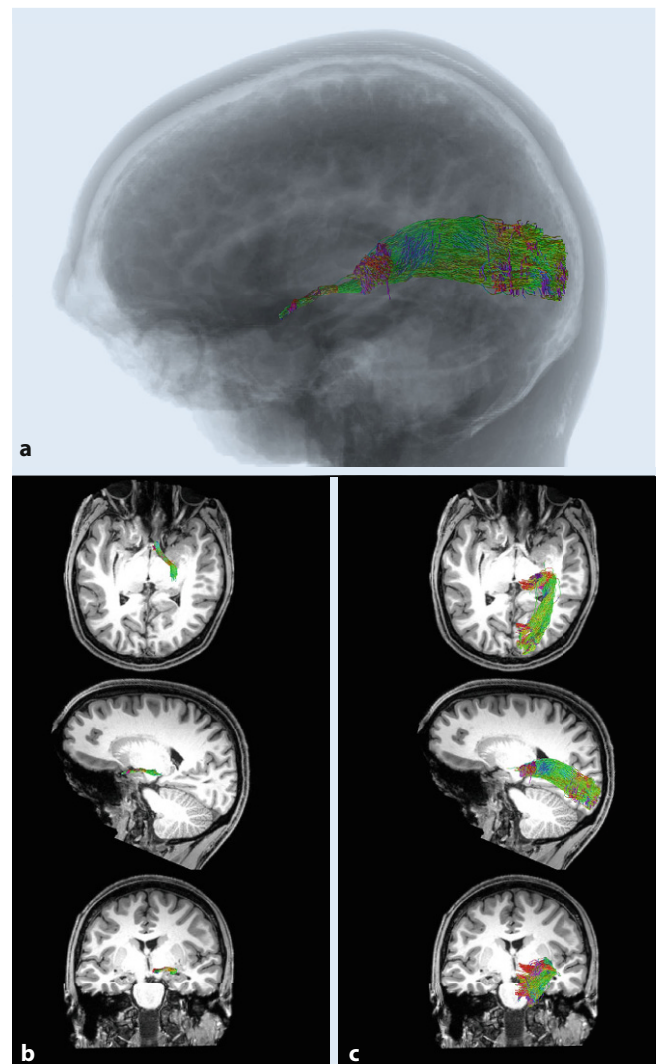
▲ Tractography of the visual pathways. a A 3D graphic in sagittal view displaying orientation of right optic tract and optic radiation streamlines. b T1-weighted images including optic tract (left) and optic tract streamlines (right) in false color (color code describes streamline orientation: green anterior–posterior; red left–right; blue inferior–superior). Streamlines are not cropped to the shown slices. (Image courtesy of Otto von Guericke University Magdeburg)
